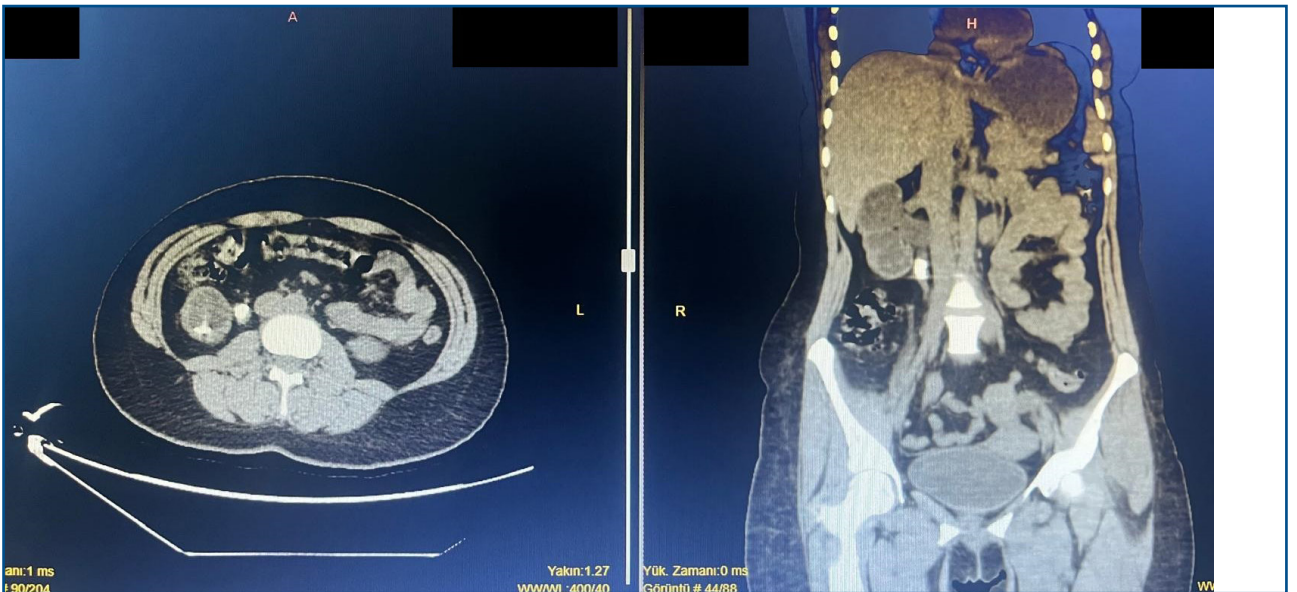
Axial and coronal CT appearance - grade 3 hydronephrosis and ureteral stone
